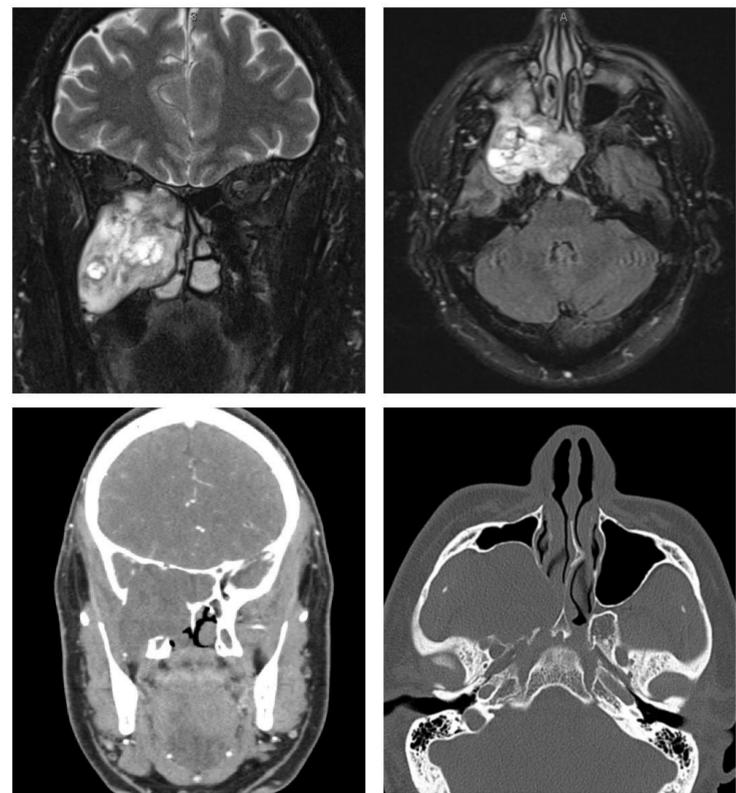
Magnetic resonance imaging and computed tomography scans from Case 1 demonstrating a large, expansile T2-bright, partially cystic tumor centered in the pterygopalatine fossa with extension into the infratemporal fossa, middle cranial fossa, maxillary sinus, and sphenoid sinus
